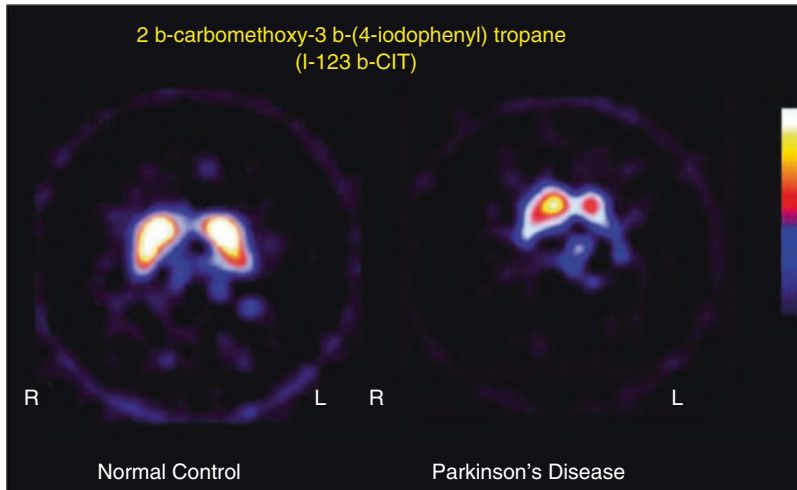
SPECT images with ^{123}I - β -CIT. Images were obtained 4 h after the intravenous injection of five mCi of I-123-b-CIT in a 57-year-old normal control (*left*) which is compared with a 62-year-old male with Parkinson's disease (*right*). The normal control shows almost complete clearance of the tracer from all cortical and white matter regions of the brain except for the corpus striatum which appear as "bright" comma-shaped objects in the center of the brain. There is symmetry comparing the left corpus striatum to the right corpus striatum. The specificity of binding is due to
